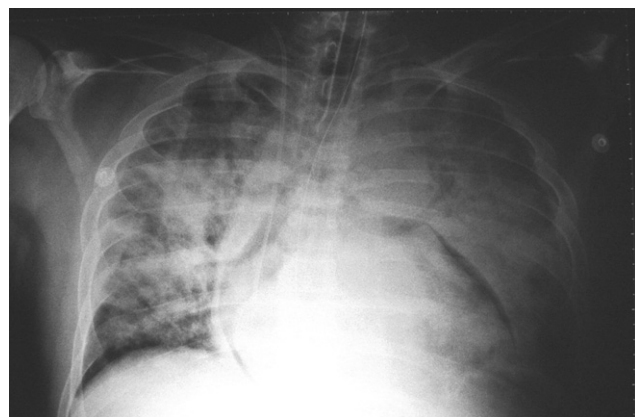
Chest radiograph shows the pneumopericardium.
